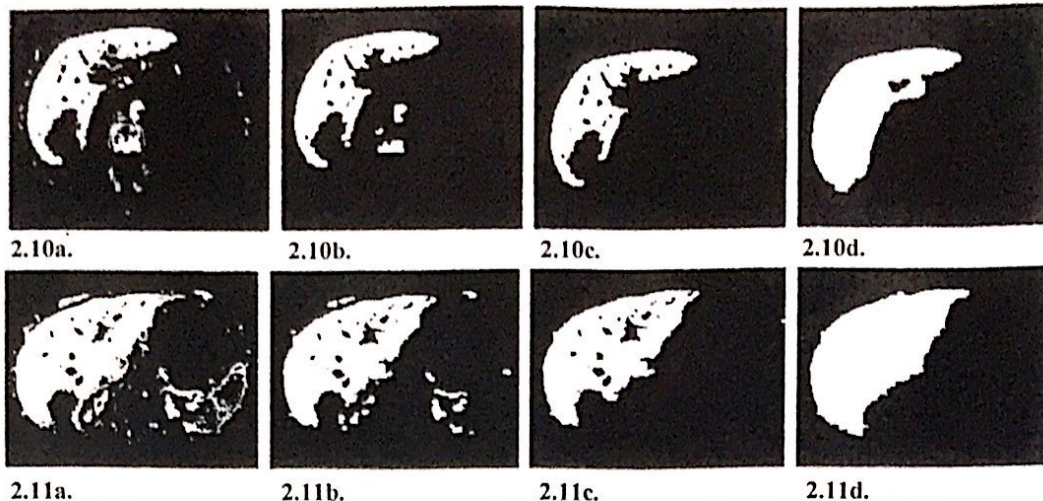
11: Binary images that result from the steps of the algorithm applied to the (CTAP image in Figure 2.9c and (4) contrast-enhanced CT image in Figure 2.9d. (2.10a, 2.11a) Thresholding of the original image. (2.10b, 2.11b) Opening of the threshold image. (2.10c, 2.11c) Extraction of the object with maximum area. (2.10d, 2.11d) Liver objects obtained by using information from adjacent sections and addition of vessels.
